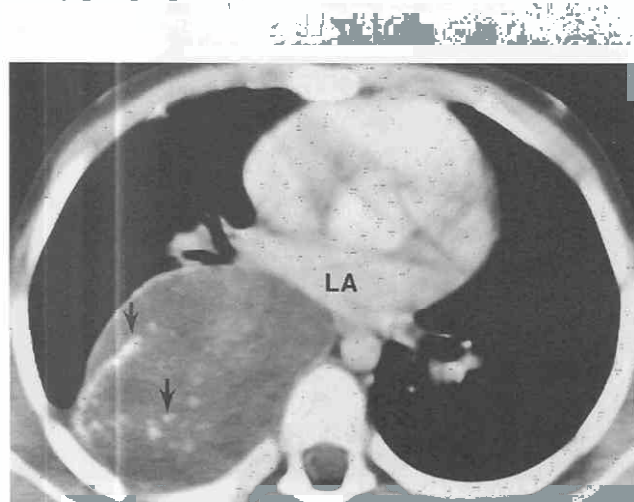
Ganglioneuroma. Contrast-enhanced CT shows well-circumscribed low-attenuation paraspinal mass containing punctate calcification (arrows). LA, left atrium.
